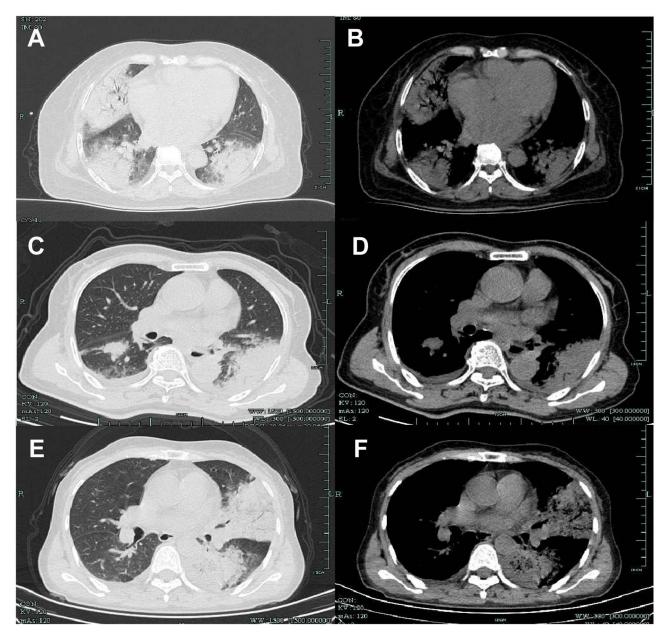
Figure I Chest computed tomography (CT) images of representative cases with psittacosis infection. Chest CT findings of a patient with multiple lobar consolidation are shown in (A) and (B). Chest CT findings of a patient with lobar consolidation, pleural effusion and nodule-like patchy consolidation are shown in (C) and (D). Chest CT findings of a patient with unilateral lobar consolidation are shown in (E) and (F).
